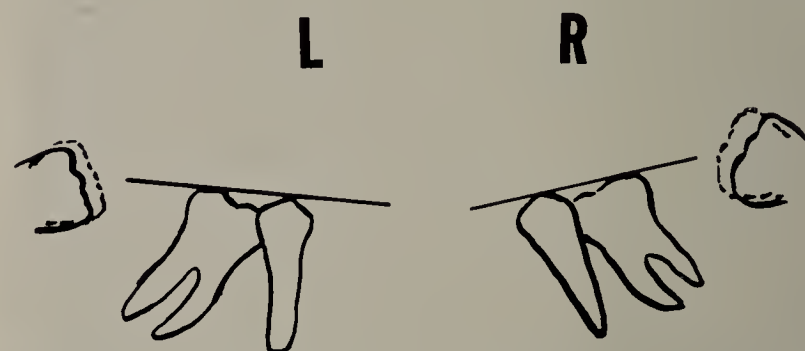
Tracing from a radiograph to show bodily mesial movement of the lower third molar.
